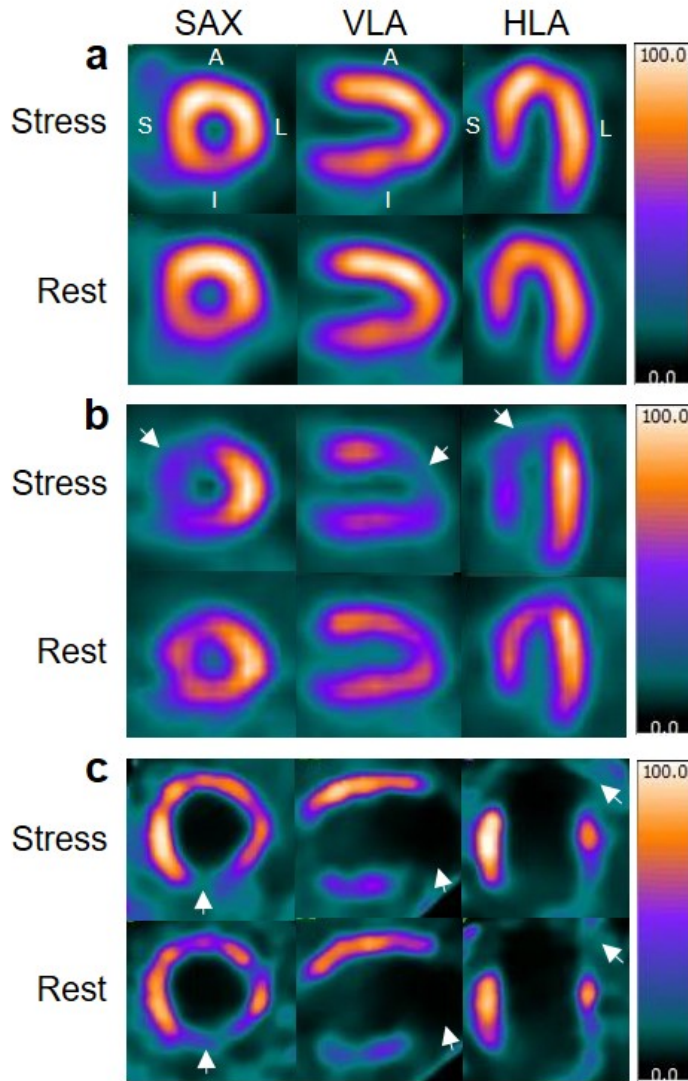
Three cases, (a), (b) and (c), of myocardial perfusion SPECT using ^{99m}Tc -tetrofosmin. Corresponding summed images of the left ventricle at stress (upper row) and at rest (lower row) are shown in short axis view (SAX), vertical long axis view (VLA) and horizontal long axis view (HLA). A – anterior wall, L – lateral wall, I – inferior wall, S – septal wall. Case (a) is an example of a normal examination. The tracer is homogeneously distributed similarly at rest and at stress. In case (b), homogeneous tracer uptake is seen at rest, whereas decreased uptake is seen in the antero-septal wall at stress (arrows), as a sign of stress-induced ischemia. In case (c), inhomogeneous tracer uptake with absent uptake in the apical and inferior parts of the left ventricle is seen both at rest and stress. This is an example of scar after a myocardial infarction.
